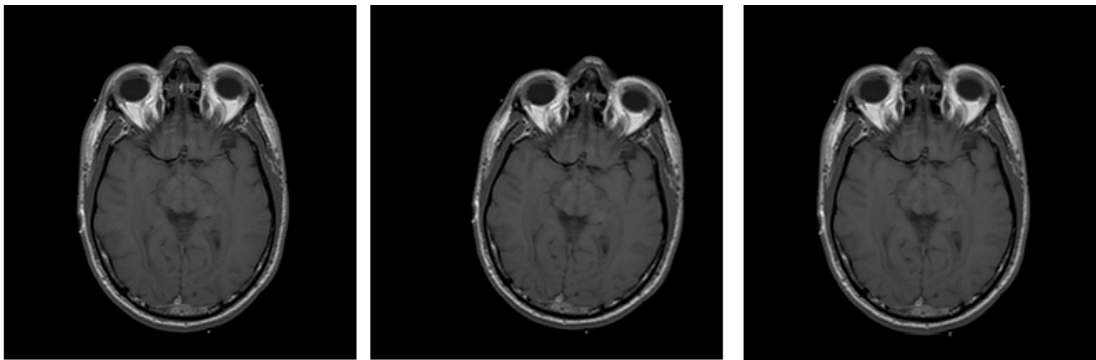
Rectification of T1-weighted MRI from HEAD test set
